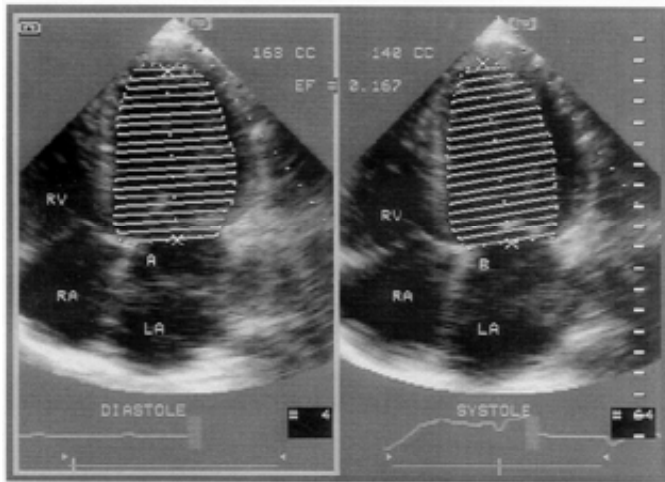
Two-dimensional echocardiography, apical four-chamber view. Modified Simpson's volumetric method for estimating left ventricular volume. After tracing the LV endocardial border, the software of the sonogram system automatically provides the volume in diastole (168 mL; left) and systole (140 mL; right) and calculates the ejection fraction (EF; 16.7%). RV = right ventricle; RA = right atrium; LA = left atrium.
